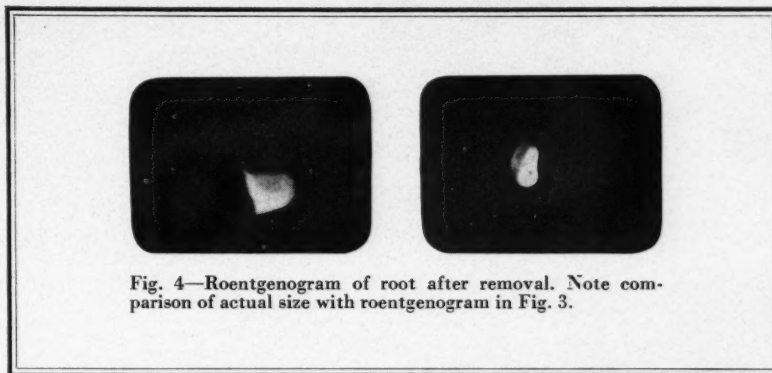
Roentgenogram of root after removal. Note comparison of actual size with roentgenogram in Fig. 3.
